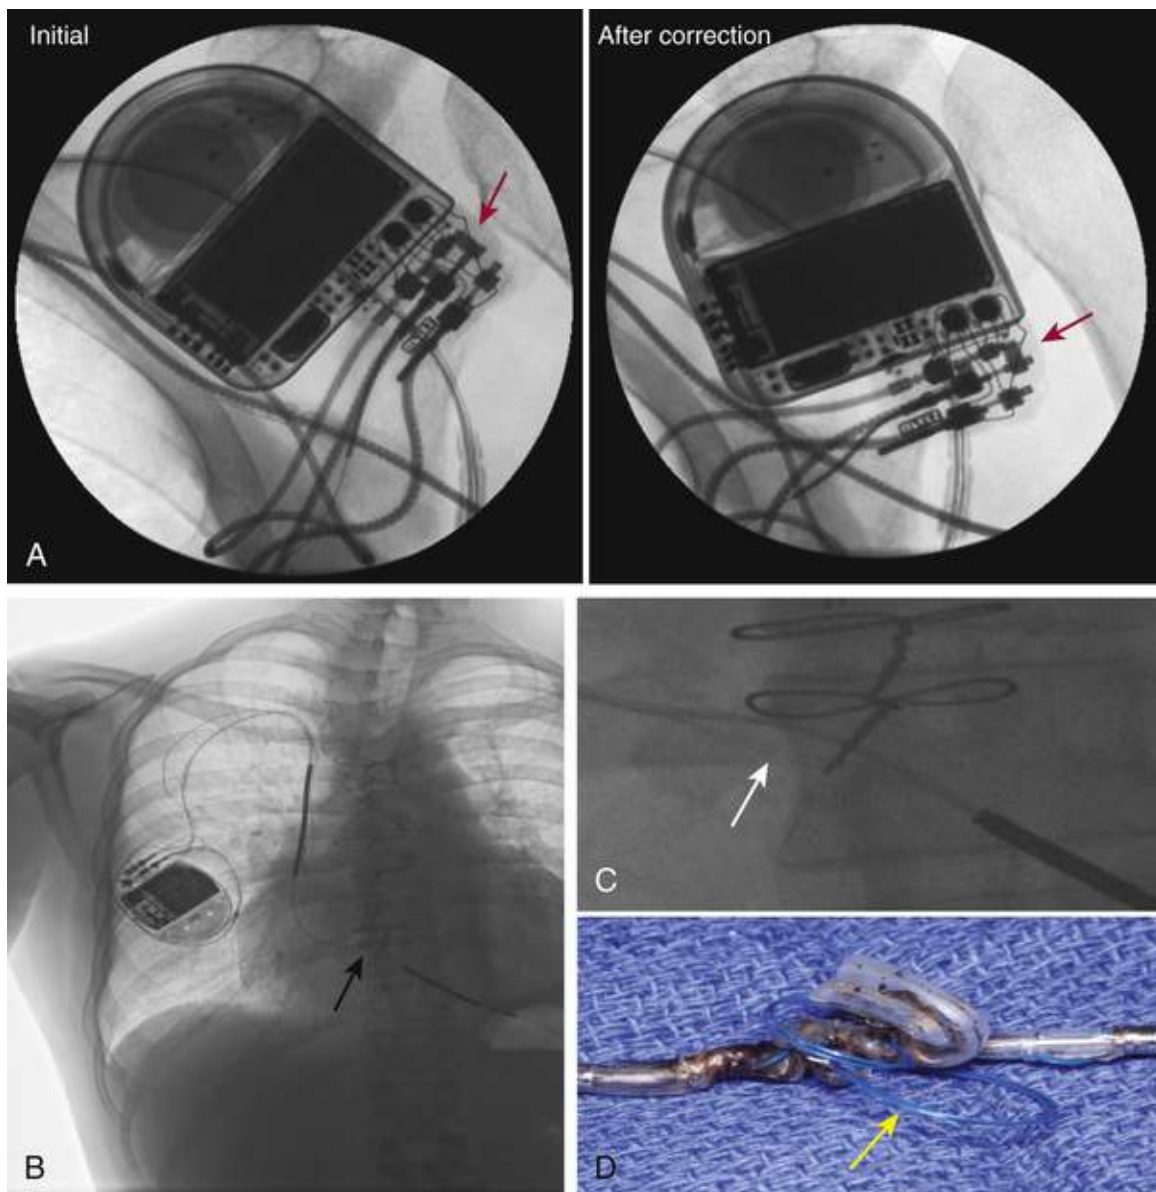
Radiography in evaluation of suspected lead failure. A, Intraoperative fluoroscopic images of a cardiac resynchronization ICD show incomplete insertion of the RV pace-sensing lead pin into the header. The ICD has been removed from the pocket to enhance image quality. Before revision, the lead connector pin was not advanced completely into the header (*red arrow*). The proximal connection between the ring electrode and the header was intermittent, which resulted in high impedance and oversensing causing pauses in the paced rhythm. After revision, the RV electrode is advanced completely into the header. B to D, Outer insulation breach of ICD lead resulting in “externalized” cables protruding out of the breach near the tricuspid valve. B, Arrow in chest radiograph indicates site of breach. These breaches typically are better seen on cine fluoroscopy. C, Magnified view. D, Photograph of extracted lead shows insulation breach with *blue* inner insulation (ethylene tetrafluoroethylene, ETFE, see [Fig. 41.1](#)) protruding from lead body. (A, From Swerdlow CD, Gillberg JM, Khairy P. Sensing and detection. In Ellenbogen KA, Kay GN, Lau CP, Wilkoff BL, editors. *Clinical Cardiac Pacing, Defibrillation, and Resynchronization Therapy*. 4th ed. Philadelphia: Saunders; 2011; B-D, From Swerdlow CD, Friedman PA, Asirvatham SJ, Hayes DL. Troubleshooting: interpreting diagnostic information. In Hayes DL, Friedman PA, editors. *Cardiac Pacing and Defibrillation: A Clinical Approach*. 3rd ed. West Sussex, UK: Wiley-Blackwell; 2014.)
